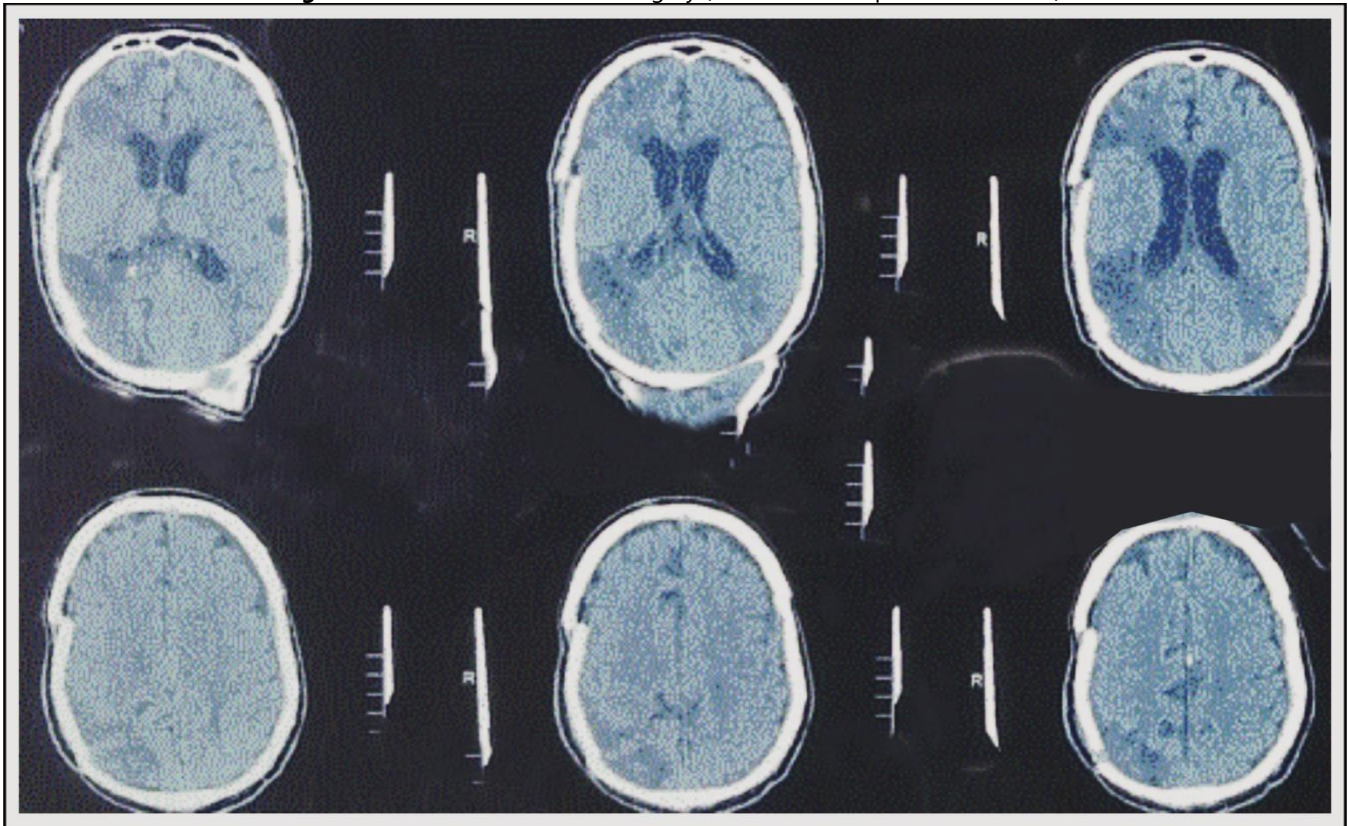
CT scan at the time of discharge (Presented after consent).
